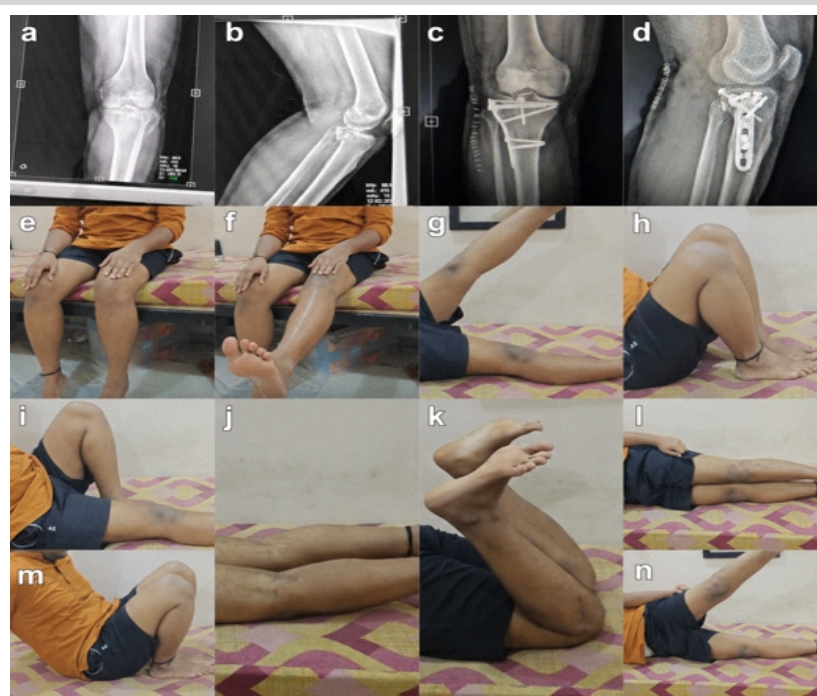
(a and b) pre-op X-rays; (c and d) post-op X-rays; (e, f, g, h, i, j, k, l, m, n) showing range of motion on 3-month follow-up.
